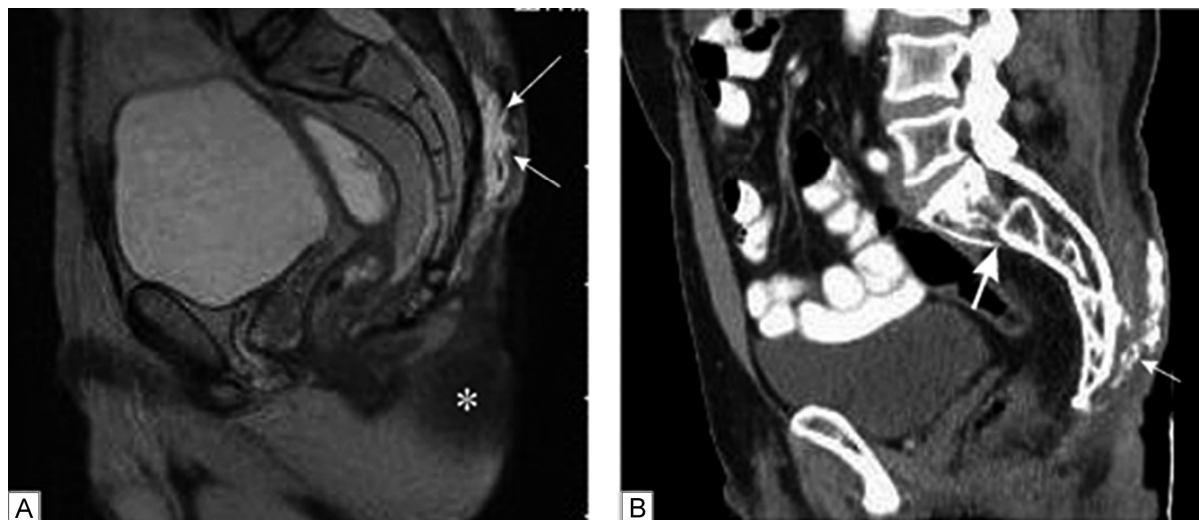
MRI and CT images of the sacrococcygeal region of the patient K. in sagittal projection: A) MRI scan: hardening of the skin, hypoderm and gluteal muscles (*), presence of pus in the hypoderm above the sacrum (arrows); B) CT scan with fistula contrasting: destruction of the I sacral vertebra (large arrow), partial bone resorption of the bodies of the II and III vertebrae; the fistula reaches the coccyx (small arrow)
